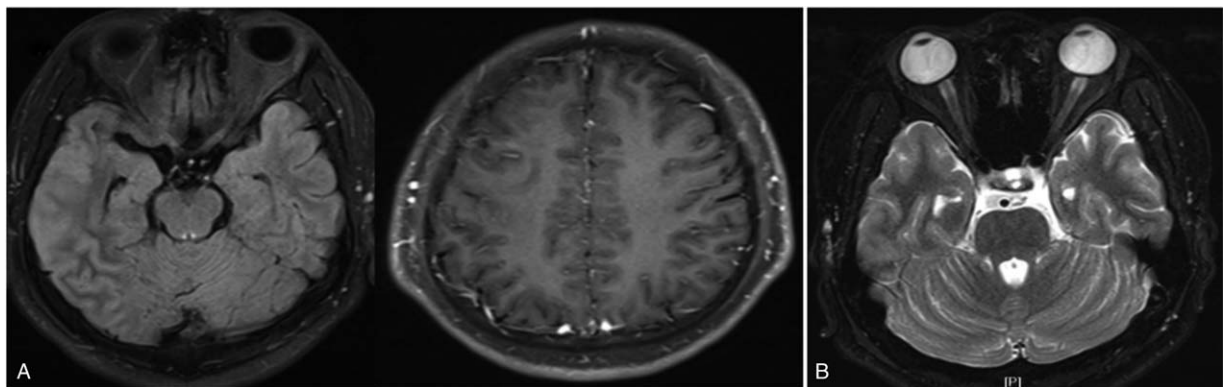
Brain MRI revealed the shallowness of the right frontal temporal lobe sulcus with contrast enhancement of the meninges (A) and orbital MRI showed T2 hyperintensities within the anterior of the bilateral optic nerve (B).
